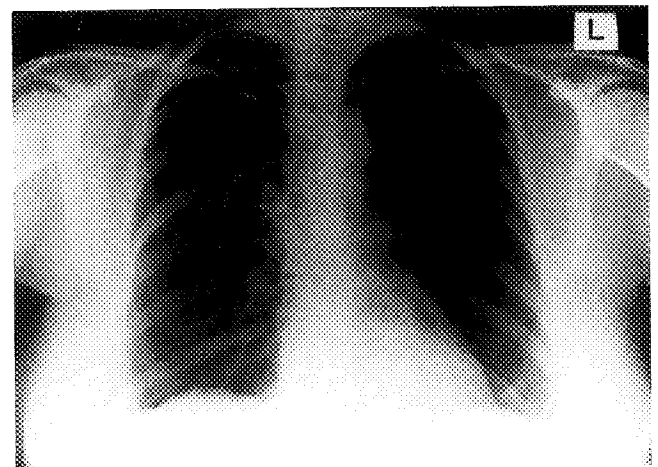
Chest radiograph showing expansile lesion involving right seventh rib and seventh thoracic vertebra.
